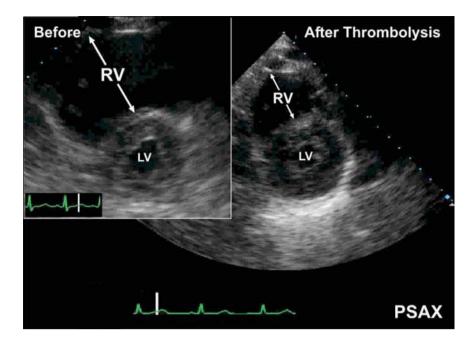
Parasternal short-axis (PSAX) views of the same patient as in Fig. 9.
